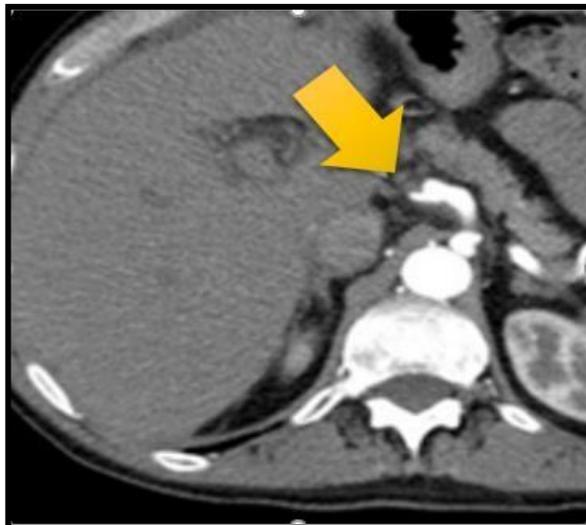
CT arteriography shows no hepatic arterial flow inside.
